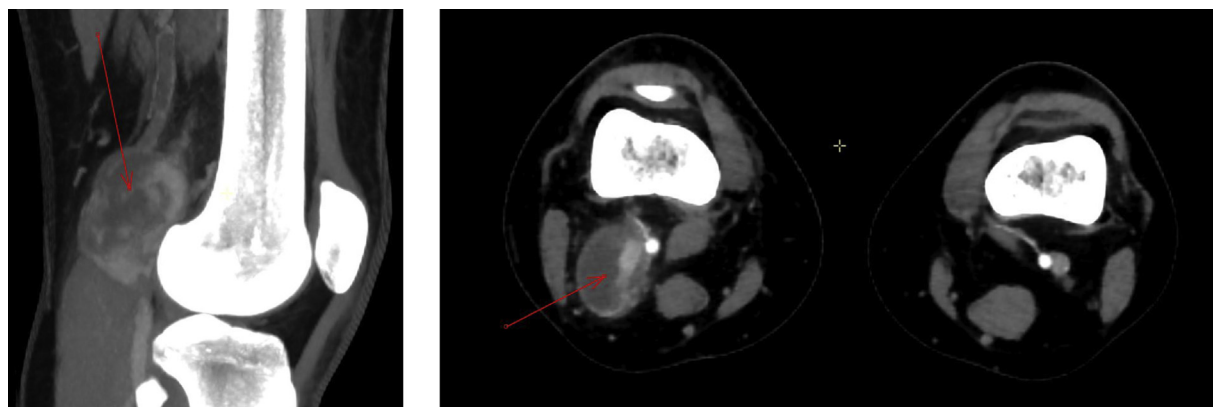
Magnetic resonance images of the popliteal venous aneurysm (PVA), sagittal section and cross-sectional view.
